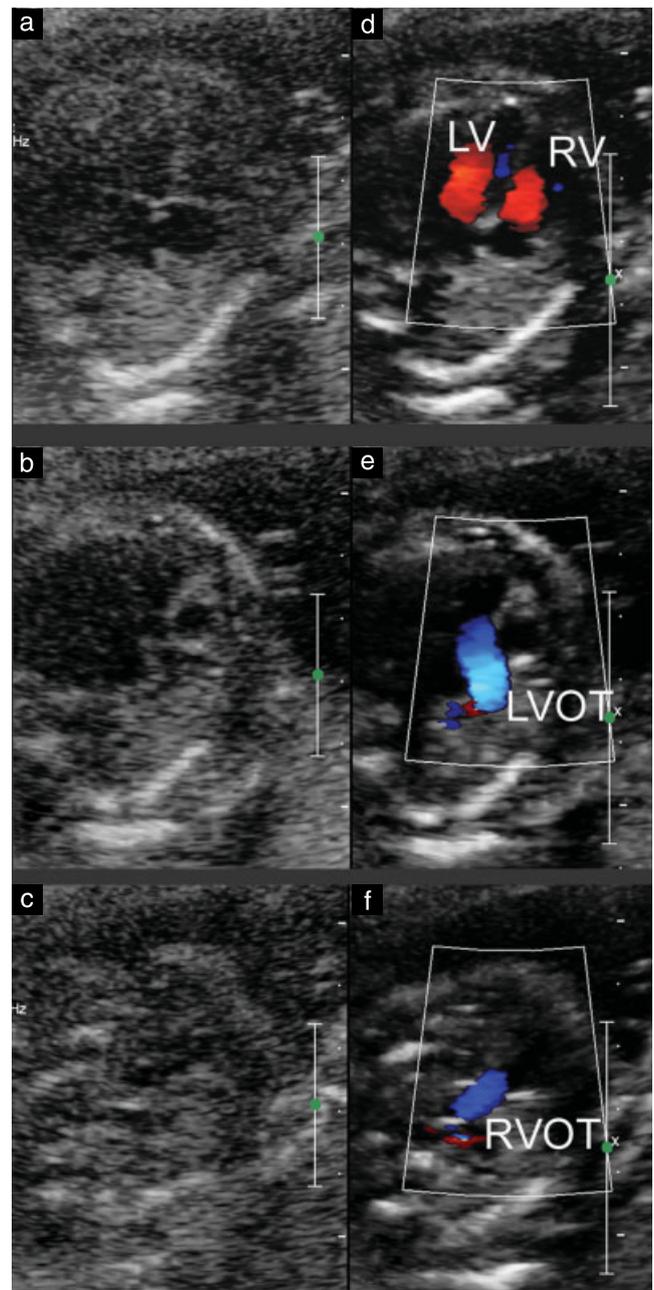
Color Doppler evaluation may help in demonstrating normal atrioventricular and ventriculoarterial connections in cases in which gray-scale ultrasound does not allow a conclusive examination due to maternal obesity. (a,b,c) Inconclusive gray-scale images of four-chamber view, left outflow tract view and right outflow tract view, respectively. (d,e,f) Corresponding color Doppler images demonstrating two normal ventricular inflows (d), an unremarkable left outflow tract (e) and an unremarkable main pulmonary artery crossing over the aorta (f), the direction of the aorta having been checked on the previous image. Normal, laminar blood flow, excluding inflow and outflow obstructions, is seen in all color Doppler images. LV, left ventricle; LVOT, left ventricular outflow tract; RV, right ventricle; RVOT, right ventricular outflow tract).
